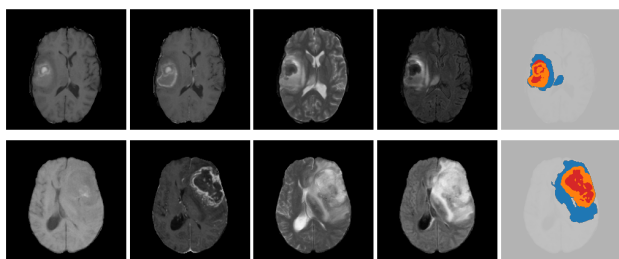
Glioblastoma segmentations from BraTS 2021. Each row contains horizontal MRI slices of the same patient, in modalities T1, T1ce, T2 and FLAIR. TC in red, ET in orange and ED in blue.
